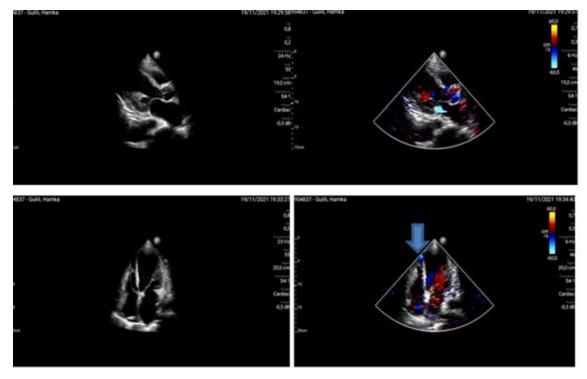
Transthoracic echocardiography in the emergency room of Dr. Wahidin Sudirohusodo Hospital's Cardiac Center on November 19, 2021.
